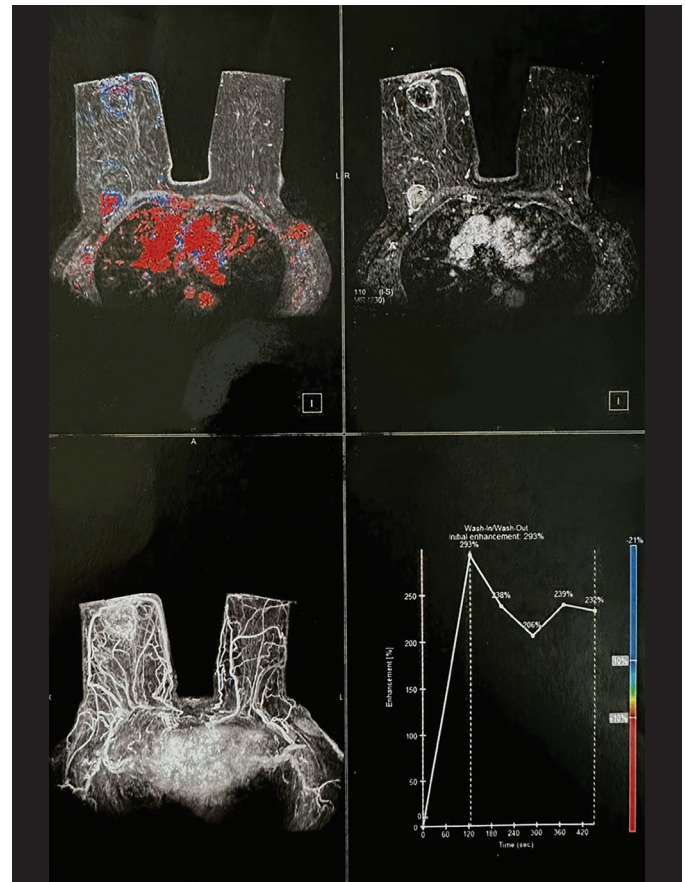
Dynamic contrast-enhanced magnetic resonance imaging of the right breast demonstrating a type III kinetic curve, characterized by rapid initial enhancement, subsequent washout, and a late plateau phase. This enhancement pattern supports the diagnosis of an aggressive malignancy
